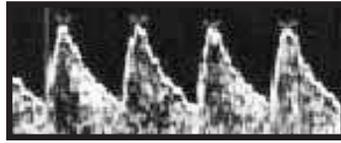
Flow velocity waveform of the umbilical artery and definitions for the different Doppler indices of resistance. FHR, fetal heart rate.
